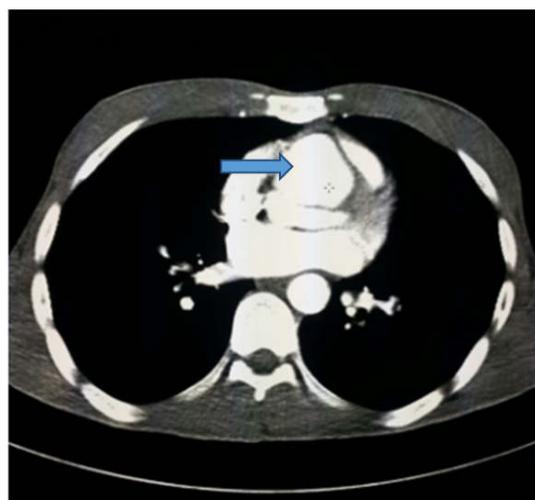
CT demonstrating the large aortic abscess of the valsalva sinus
